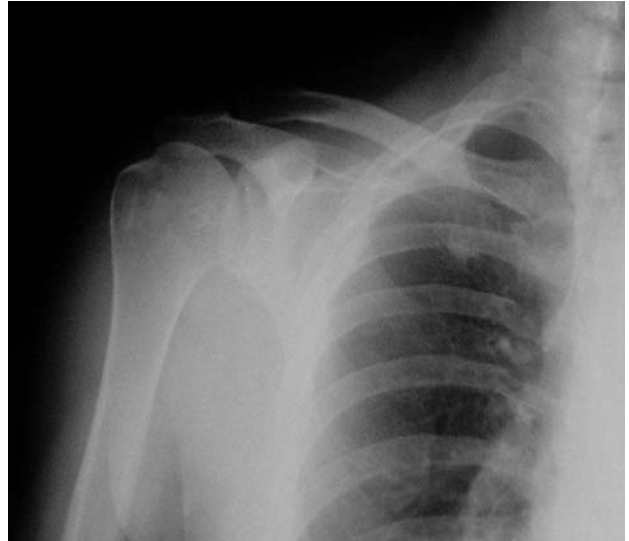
Postoperative anteroposterior radiograph of the patient at 4 years.
